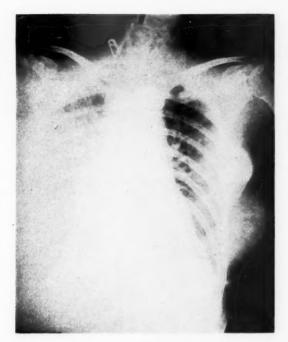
Roentgen ray film of chest May 6, 1933, showing area occupied by mediastinal abscess and drainage catheters in place. The right pleural effusion is also evident.
